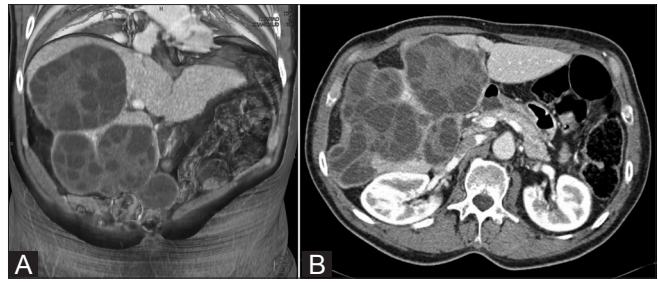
(A,B): Preprocedure volume rendered CT scan reconstructions show multiple multivesiculated, honeycomb-like, hydatid cysts (type CE2) at the level of the VIII–VII and IV liver segments (A) and within the V–VI liver segments (B)
